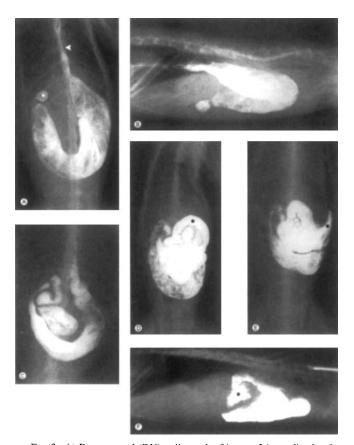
A) Dorsoventral (DV) radiograph of iguana 2 immediately after barium administration. Note residual barium in esophageal folds (arrowhead), U-shaped stomach, pyloric antrum, and duodenal bulb (asterisk). B) Lateral radiograph of iguana 2 immediately after barium administration. Note dorsal position of descending stomach to ventral position of ascending stomach. The duodenal bulb is identified cranio-ventrally. C) DV radiograph of iguana 4 made 30 minutes after barium administration. Note barium in pyloric antrum, descending and ascending duodenum. Descending stomach is emptying of barium. An impression in the ascending stomach wall due to peristalsis can be identified. D) DV radiograph of iguana 1 made 2 h after barium administration. The stomach is largely empty while the small intestine is filled with barium. Note the cranial loop (asterisk) present in the left cranial quadrant. E) DV radiograph of iguana 3, made 4 h after barium administration. Note barium within ileum located along the left flank (asterisk). F) Lateral radiograph of iguana 3 made 6 h after barium administration. Note ventral position of stomach and small intestines, all of which are overlapped. The ileum can be identified lying dorsal to small intestine and entering the first compartment of the large colon on the dorsal aspect (asterisk).
